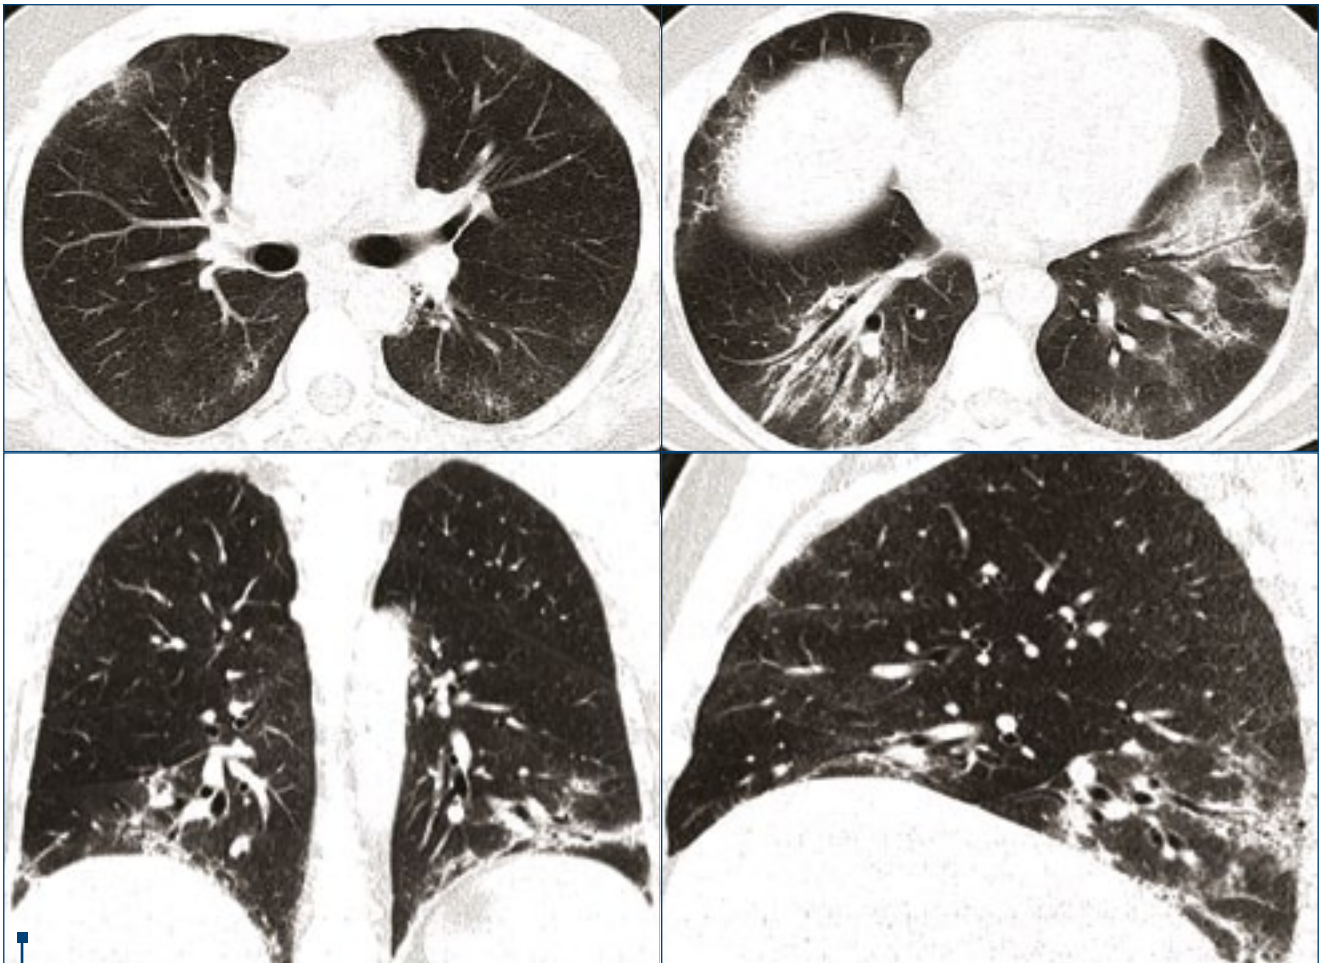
High resolution CT scan of the lungs suggestive of NSIP pattern
